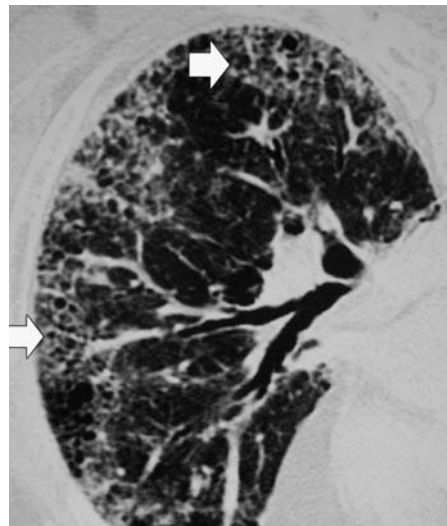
Prone thin-section computed tomography of an asbestos miner showing areas of subpleural peripheral honeycombing (small cystic spaces a few millimetres in diameter) (arrows)
